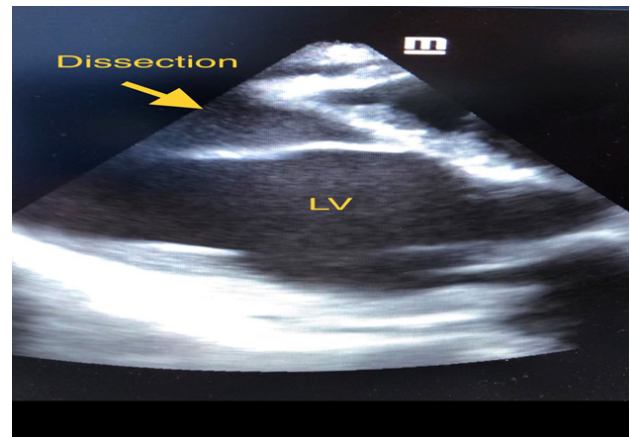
Echocardiography imaging showing left ventricular dissection involving mid and apical anteroseptal segment
